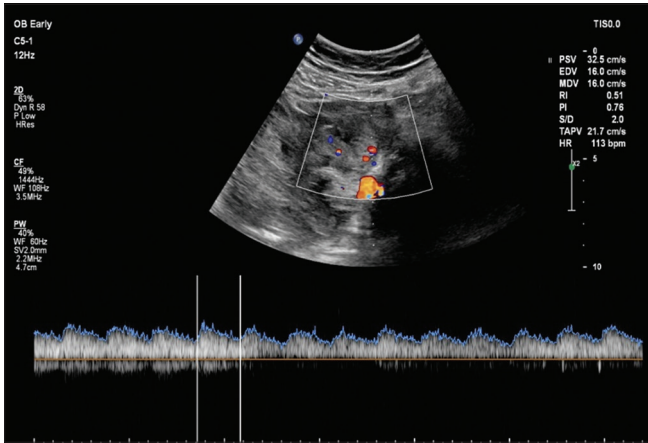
Doppler of ectopic pregnancy
